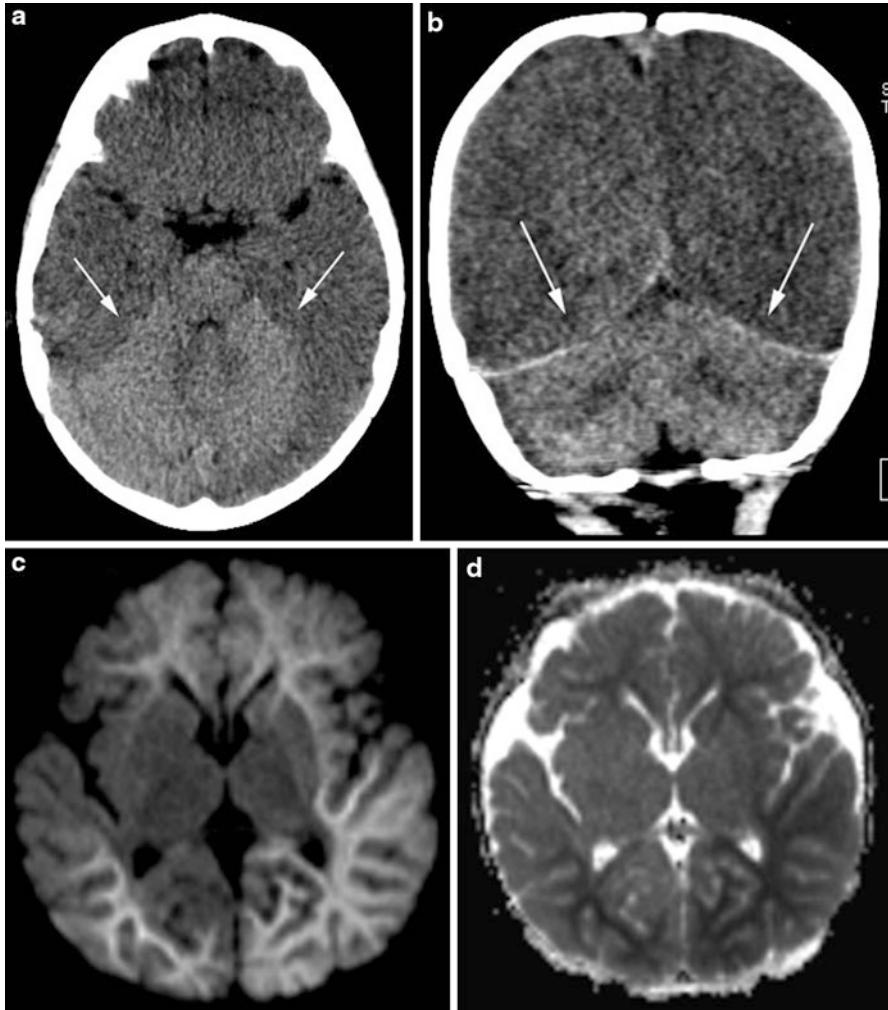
White cerebellum sign. 5-month-old brought in by caregiver for lethargy. Noncontrast axial (a) and coronal (b) CT images demonstrate relative diffuse hypodensity of the supratentorial brain. Compared with the supratentorial brain, the normal cerebellum appears hyperdense (arrows). A follow-up MRI demonstrates widespread areas of decreased diffusion which is bright on the diffusion-weighted image (c) and dark on the corresponding ADC map (d). These findings are compatible with diffuse hypoxic injury. Notice also the relative sparing of the deep gray nuclei
